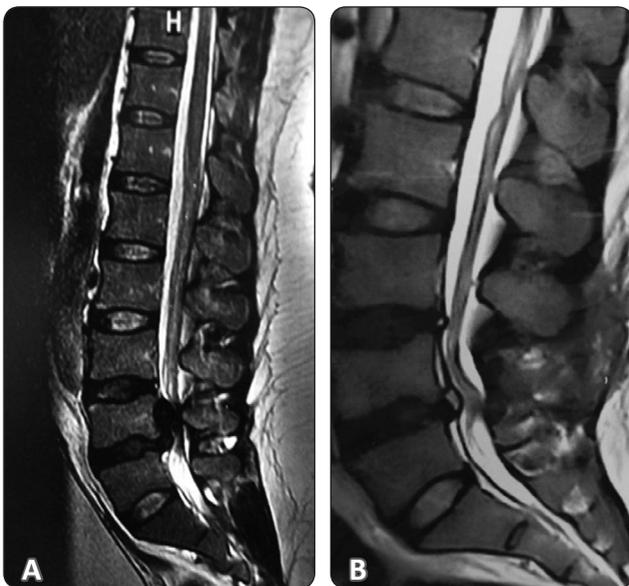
Forty-six years old female presented by bilateral foot drop with weakness of right lower limb proximal and distal. (A) Preoperative sagittal MRI showing huge upward migrated L4/5 disk propels comprising the whole cauda equina. (B) Postoperative sagittal MRI shows residual disk herniation. The patient had incomplete resolution of the preoperative clinical signs.
